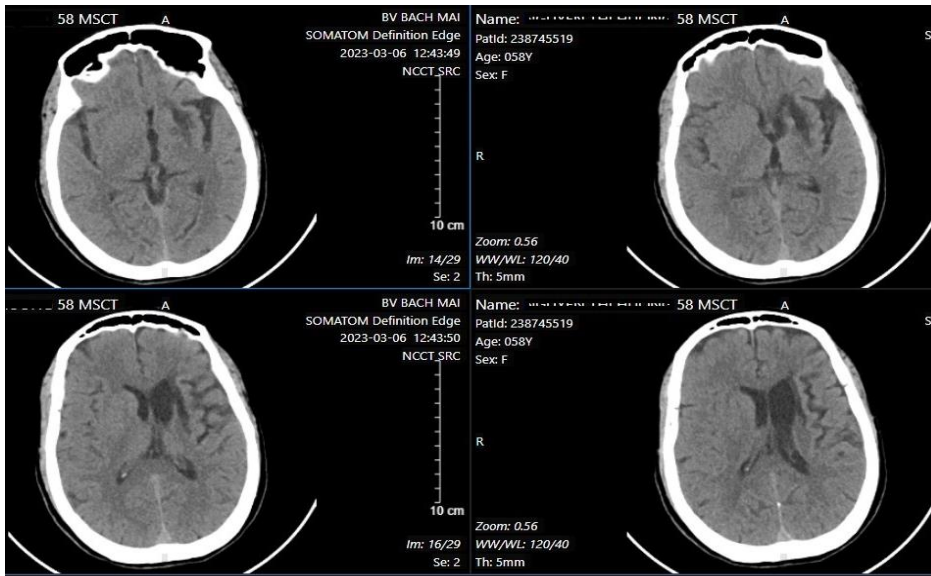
Image of brain parenchyma on CT film at hospital admission
